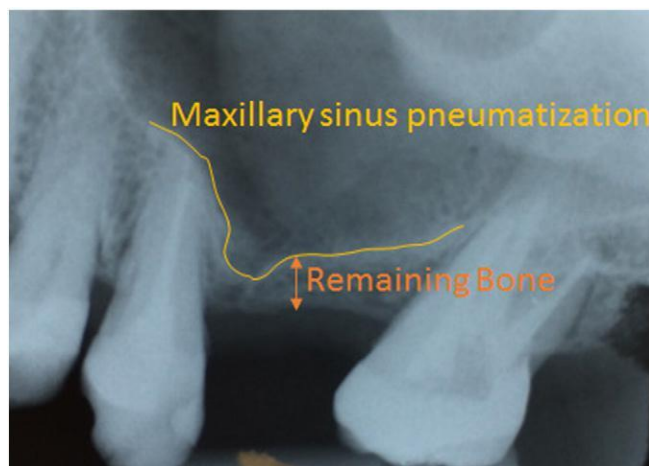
Example of bone draft demand in oral surgery. Maxillary sinus pneumatization caused by loss of tooth, where the installation of dental implant is not possible by the lack of bone height. Radiograph assigned by Victor Z Martin DDs. (Adapted from [13]).
